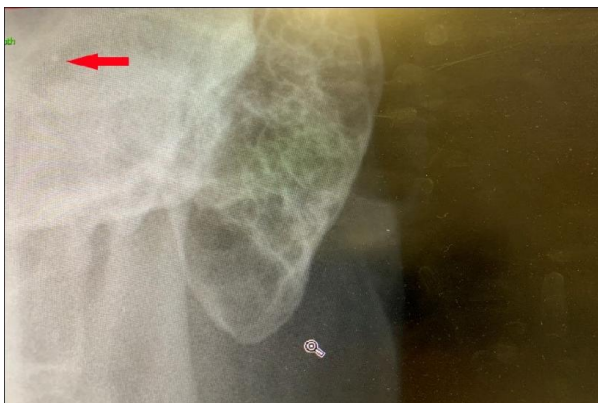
X-ray of mastoid showed suspected metal FB
